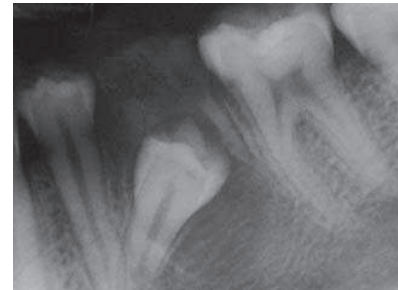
Periapical radiograph showing a carious 75 and a well defined radiolucency with a faint sclerotic border around the apex of mesial root of 75 encircling the crown of impacted 35 extending up to the middle third of root of 35.
